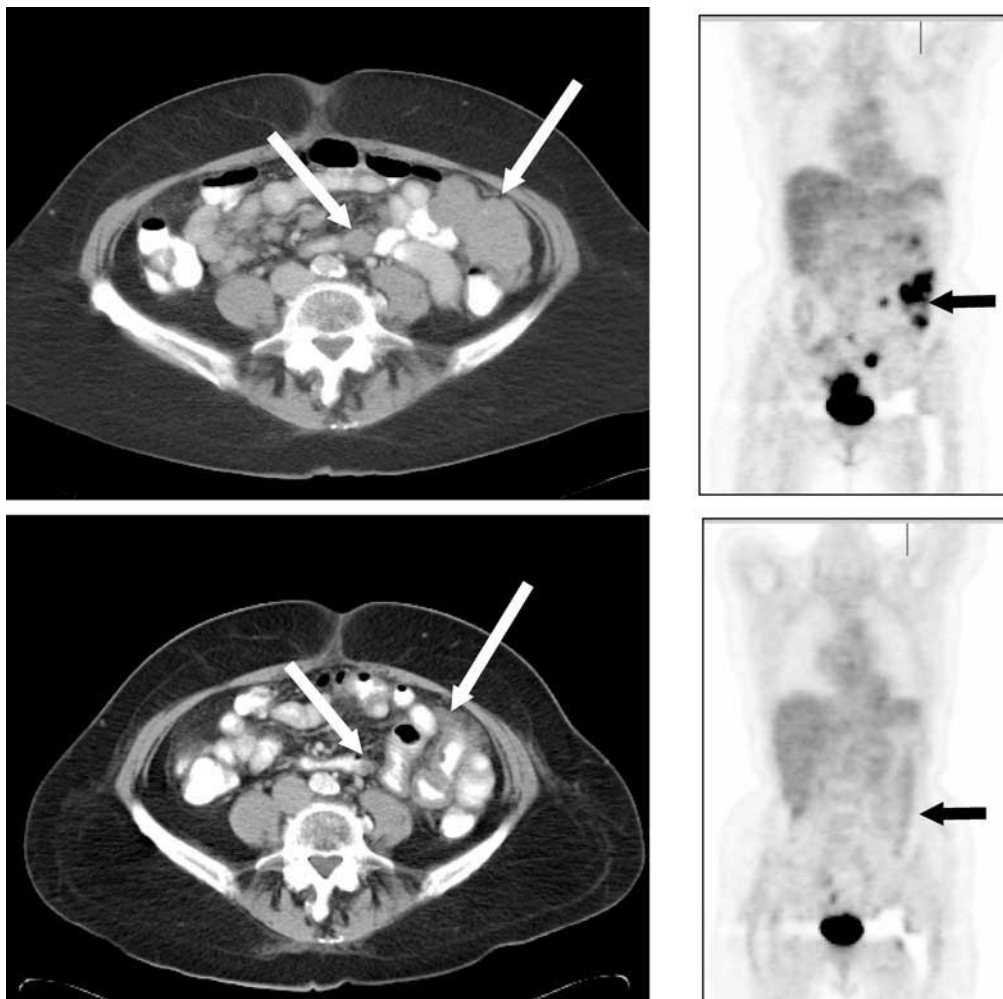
Clinical response to STI-571 in a patient with advanced, metastatic GIST. Response of a patient with intraperitoneal GIST before (top) and 3 months after (bottom) STI-571 therapy by CT (left) and PET scan (right). Notice that the tumor nearly disappeared by CT imaging and became "cold" on the PET scan after treatment. (Prepared with the assistance of Dr. Annick van den Abbeele and Dr. Milos Janicek, Dana-Farber Cancer Institute, Boston MA.)
